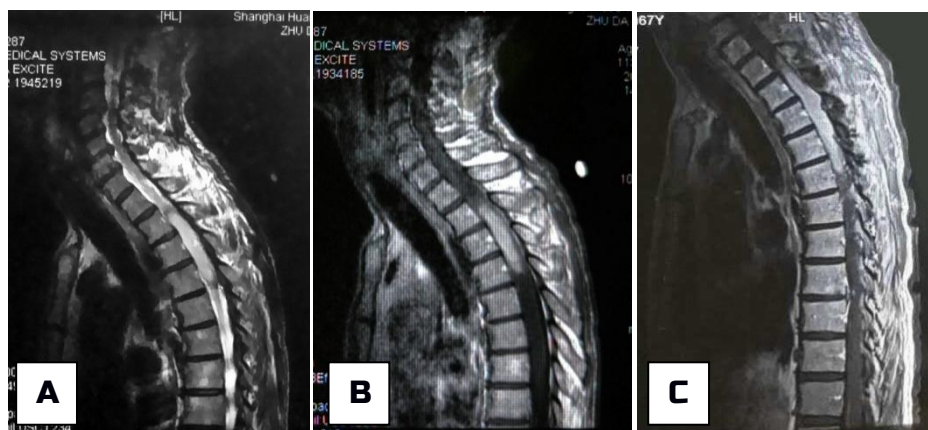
Preoperative T2-weighted (A) and Gd-enhanced T1-weighted (B) MR images show an intramedullary lesion at T2–T4 level. (C) Gd-enhanced T1-weighted MRI 4 months after the surgery and irradiation therapy show the lesion to have enlarged from T1 to T5.
